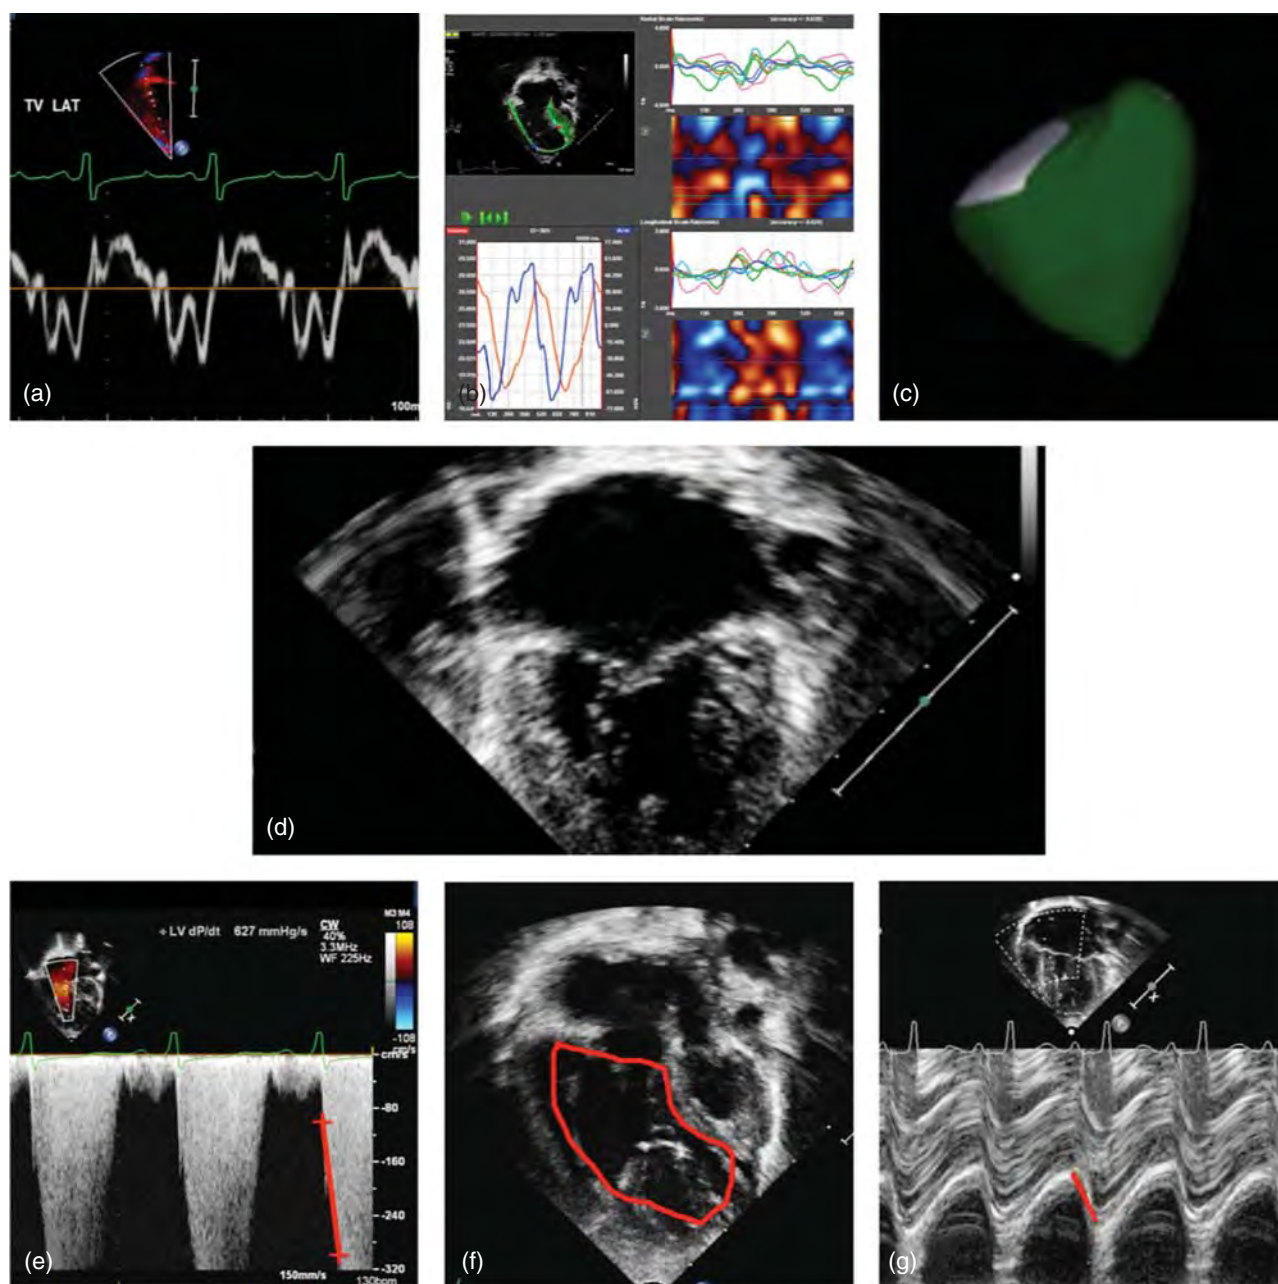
Methods for the assessment of RV function in HLHS: (a) tissue Doppler; (b) speckle tracking; (c) three-dimensional echocardiography; (d) subjective visual assessment; (e) change in pressure by time (dP/dT); (f) fractional area change (FAC); (g) tricuspid annular plane systolic excursion (TAPSE).
